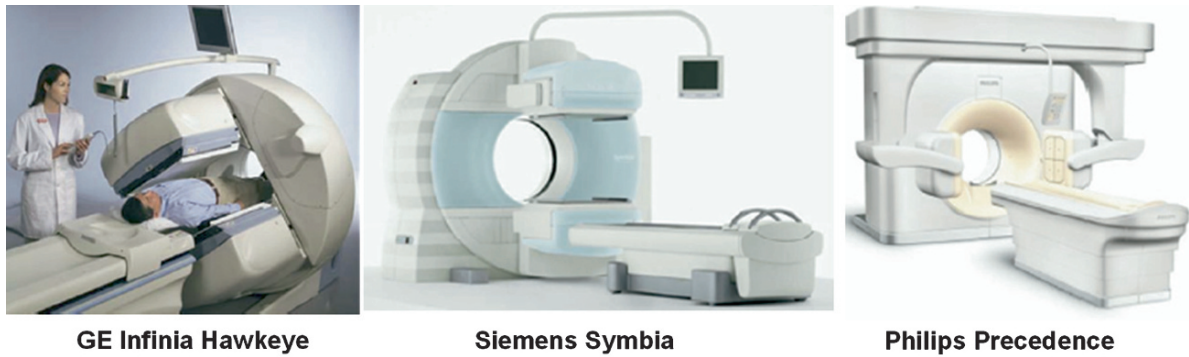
SPECT/CT systems in routine clinical use
